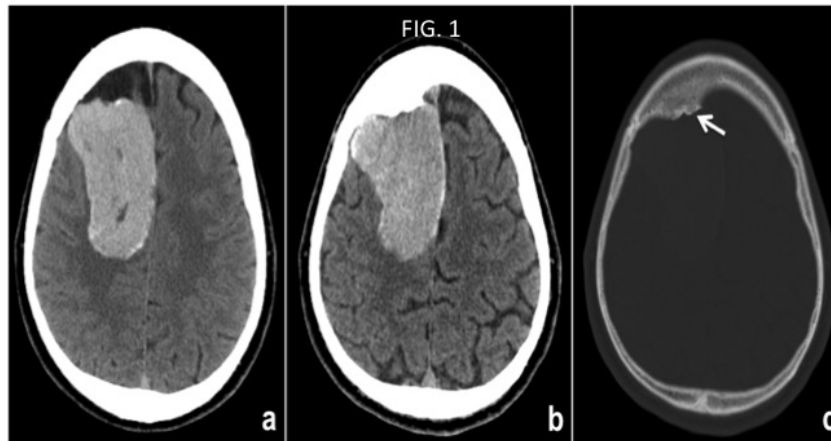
Unenhanced CT scan shows a well-defined, hyperdense and inhomogeneous extra-axial lesion (a-b), with mass effect on the adjacent brain structures. CT scan with bone algorithm (c) shows a clear planting base on the inner surface of the cranial vault, with thickening of the internal wall of the frontal bone (*white arrow*).
